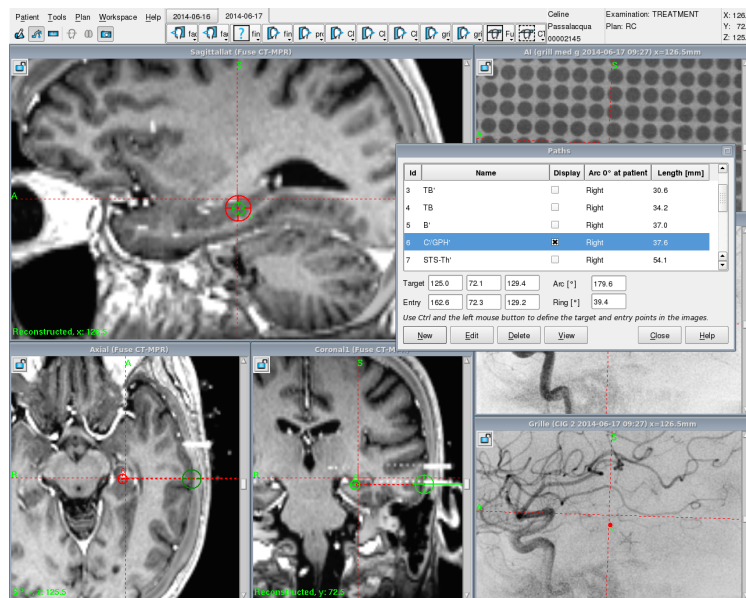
Modern MRI and angiogram visualisation of electrode trajectory (top panel) and computerised planning of electrode trajectory (bottom panel).
